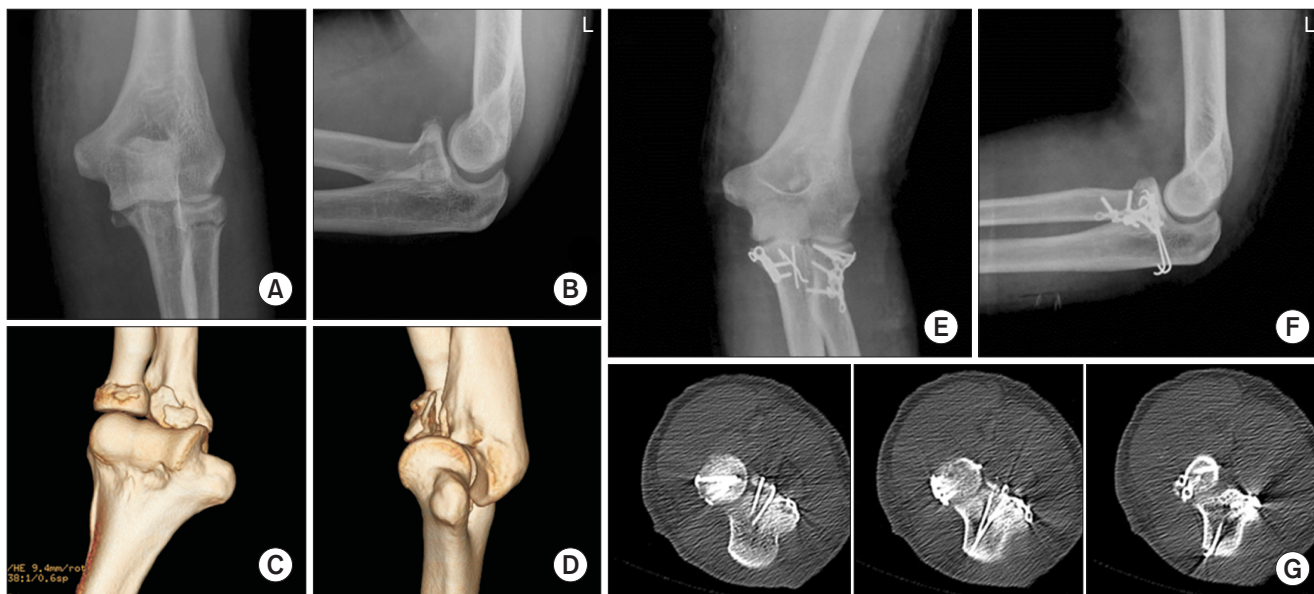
(A-D) A 28-year-old male patient was diagnosed with a type II coronoid process fracture (tip fracture type) accompanied by a radial head fracture. (E, F) The coronoid process was fixed with a mini buttress plate using the hooked Kirschner wire technique. (G) Computed tomography images obtained after fixation.
